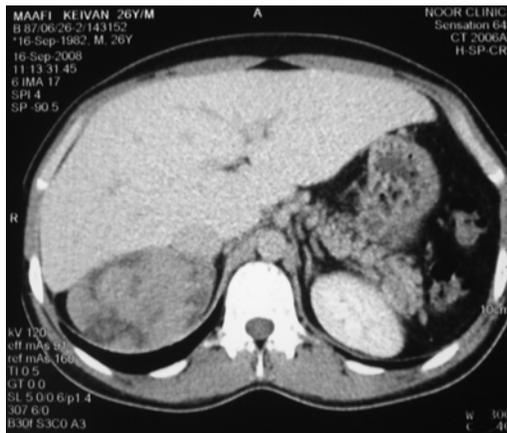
Abdominal CT scan of the patient, spleen is not observed.
